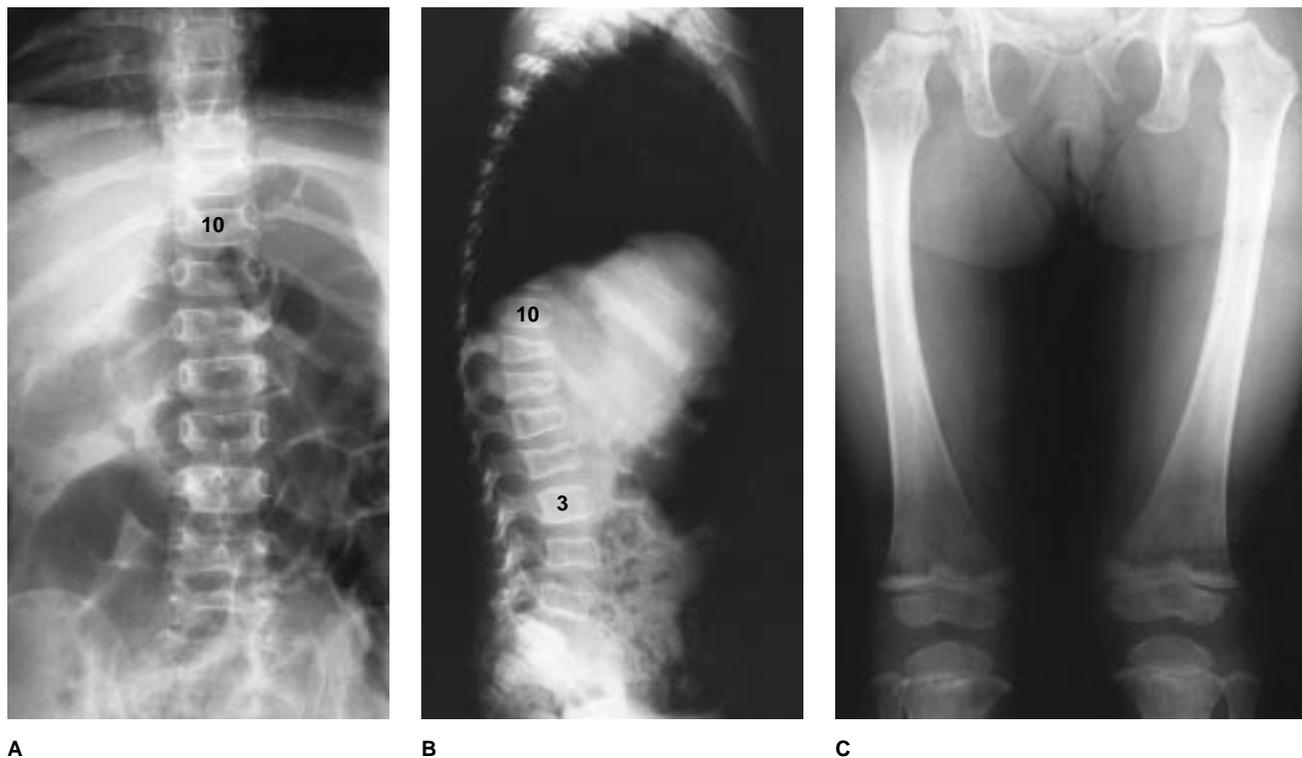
Anteroposterior (A) and lateral (B) radiographs of the thoracolumbar spine of a 2-year-old child with new onset of back pain show multiple compression fractures at T11–L2 and generalized osteopenia. C, Metaphyseal bands in the distal femurs.
